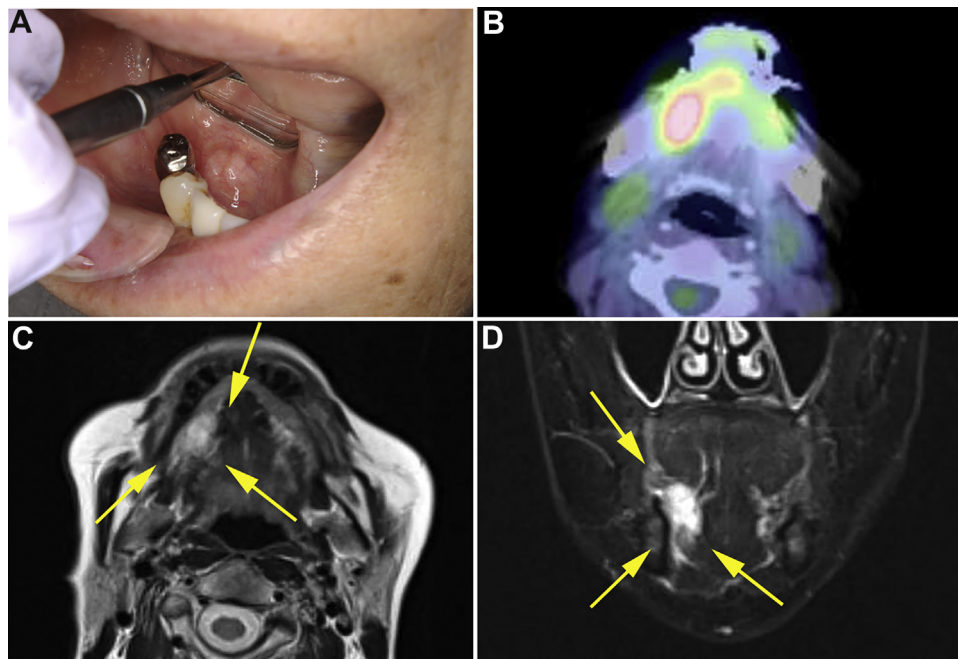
Intraoral photography and imaging examination findings. (A) The tumorous mass on the right side of the oral floor. (B) Positron emission tomography-computed tomography showing an irregular mass with an SUVmax of 7.6. (C,D) Magnetic resonance imaging showing an indistinct marginal mass with high intensity on T2-weighted imaging (yellow arrows).
